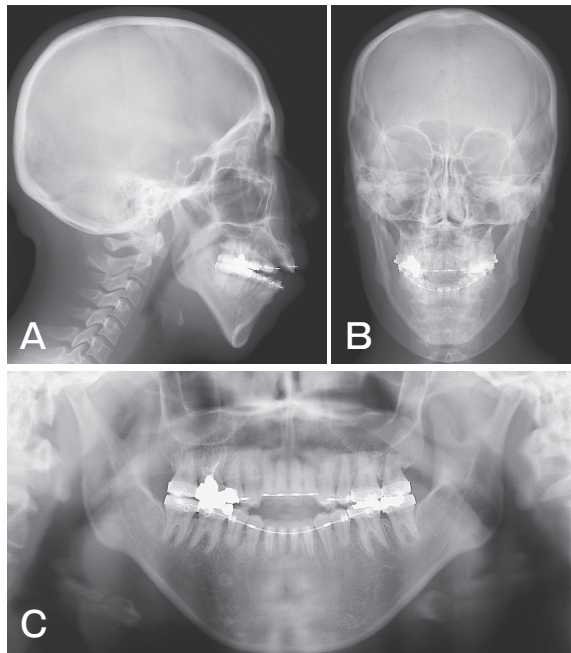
Pre-surgery radiographs. A, Lateral cephalogram; B, Posteroanterior cephalogram; C, Panoramic radiograph.
